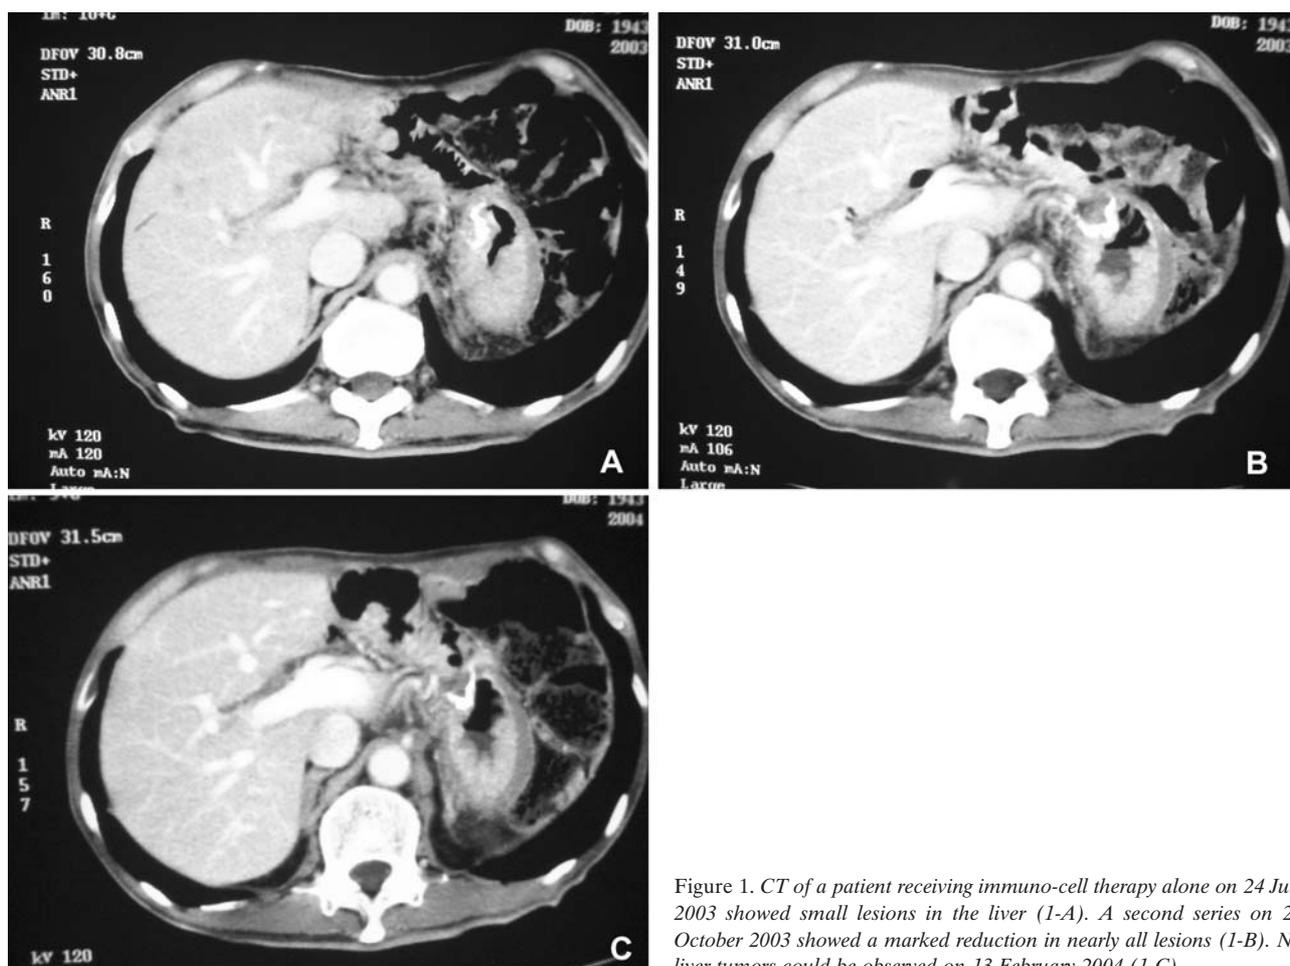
CT of a patient receiving immuno-cell therapy alone on 24 July 2003 showed small lesions in the liver (1-A). A second series on 29 October 2003 showed a marked reduction in nearly all lesions (1-B). No liver tumors could be observed on 13 February 2004 (1-C).
